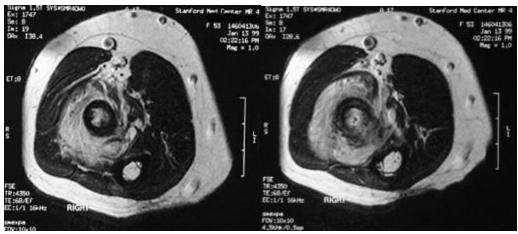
MR imaging: Axial FSE T2
